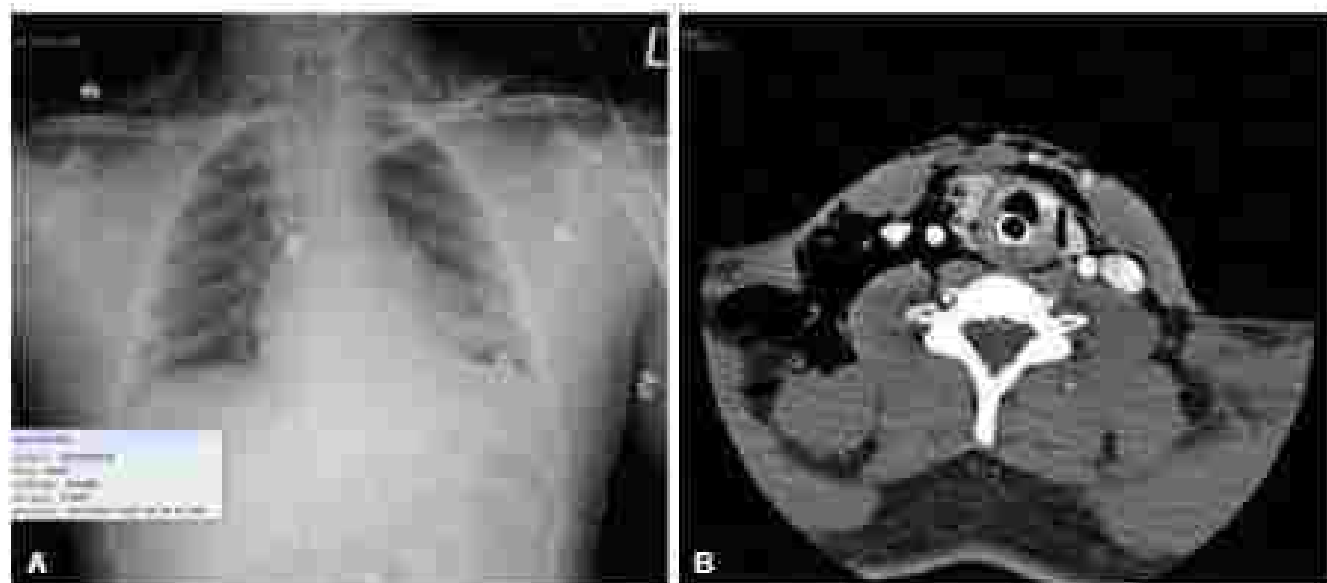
A 25-year-old male sustained a gunshot wound to the anterior neck. He was noted to have an airway injury from the wound with forceful coughing and talking. On chest radiograph, the bullet was seen in his mediastinum. He was electively intubated in the operating room to ease an emergent surgical airway was necessary. Imaging revealed massive subcutaneous emphysema and retracted air. He was taken back to the operating room for bronchoscopy and esophagoscopy, which revealed injury to both his trachea and his esophagus. His esophageal injury was approached via transcollarotomy incision and repaired with I-D PDS and buttressed with a portion of strap muscle. The tracheal injury was small and not repaired. The patient was extubated and underwent an unremarkable upper gastrointestinal swallow study before initiation of a diet.
